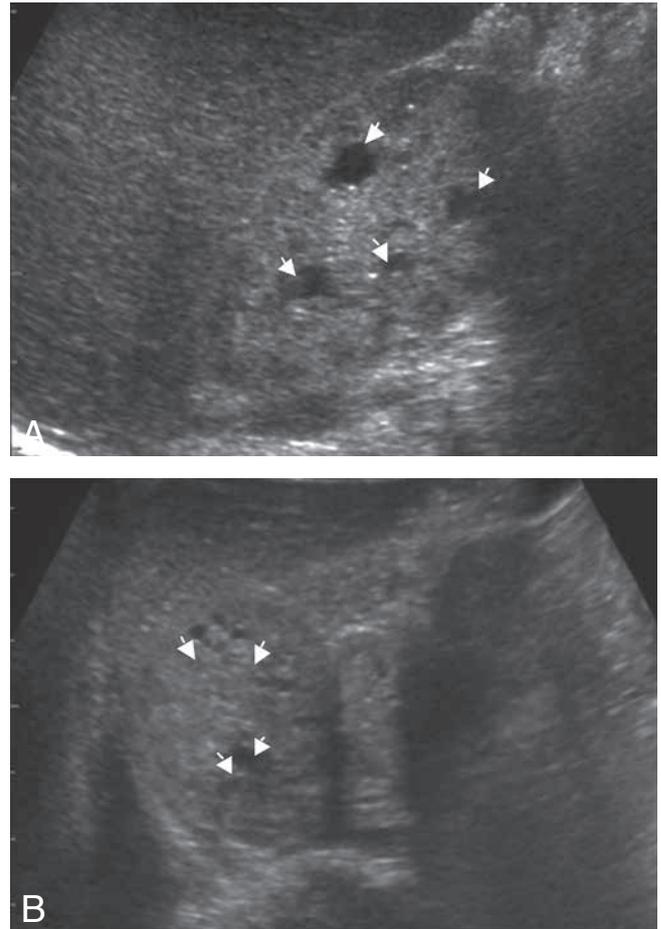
4-year-old. Transverse ultrasound scans (A and B) show multiple cysts in the medullary areas (arrows).
